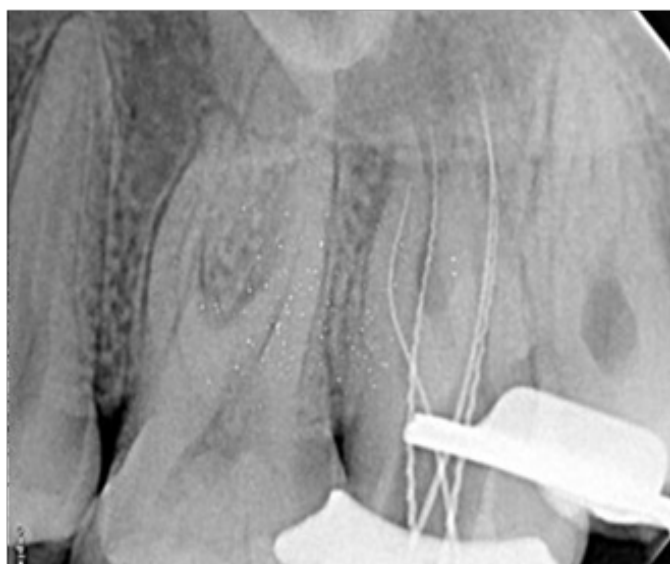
Radiograph with working length.
